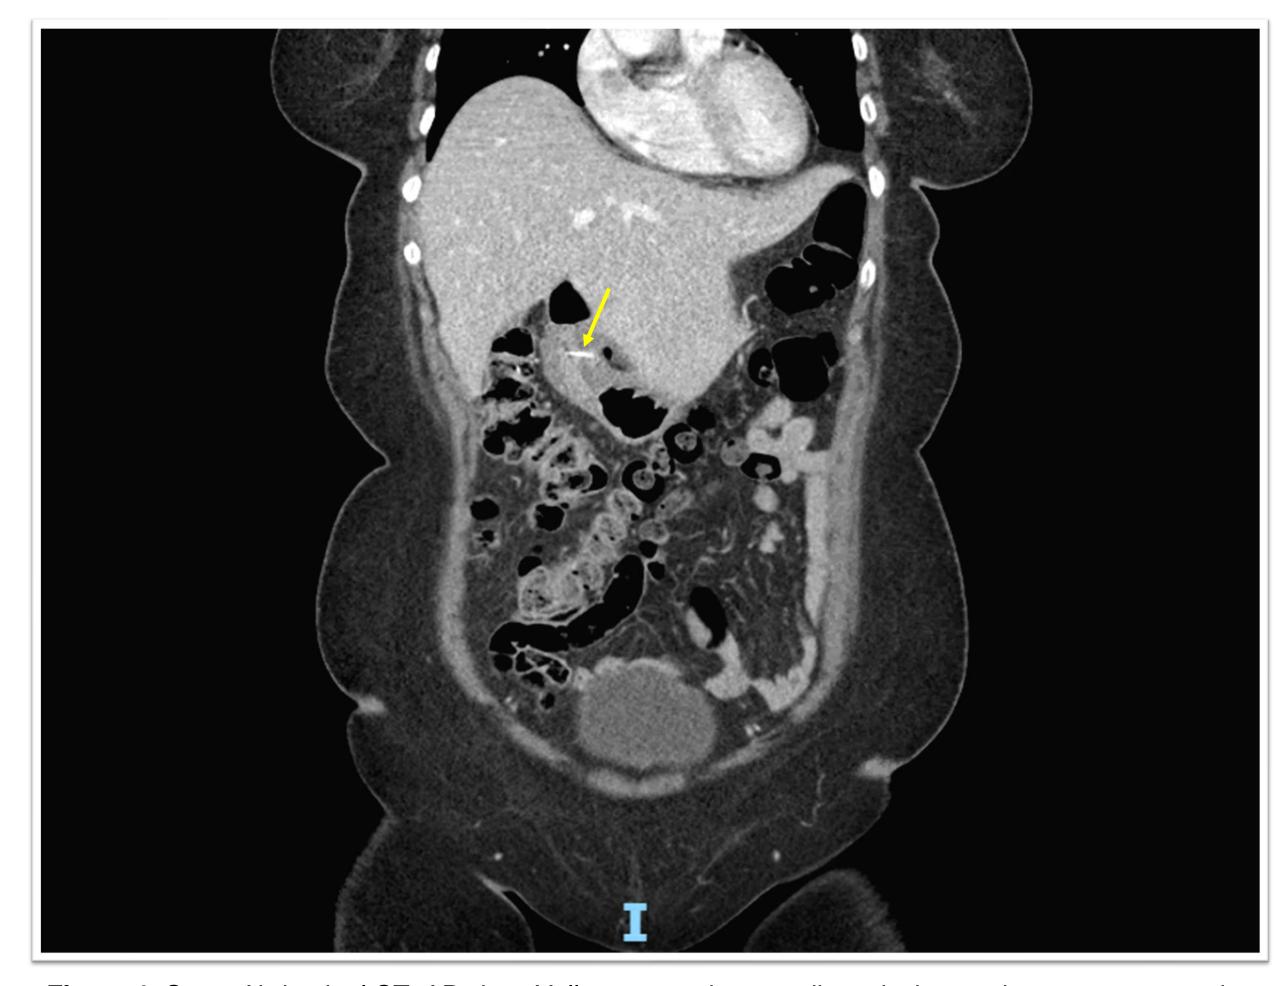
Scout Abdominal CT, AP view. Yellow arrow shows radiopacity in gastric antrum, suggestive of foreign body.
